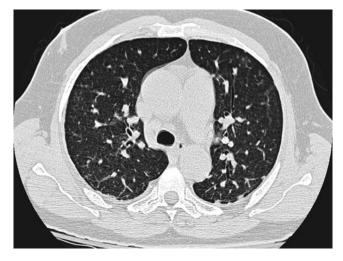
Chest CT scan demonstrates multiple subcentimeter nodules in both lungs.
